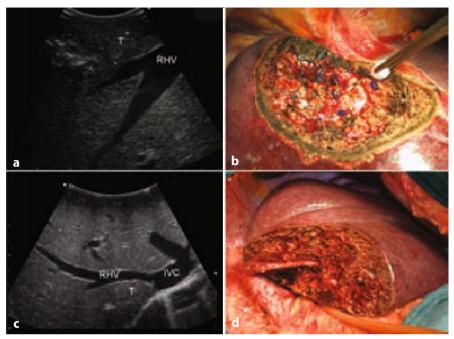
Parenchymal-sparing strategy in resection of colorectal liver metastases. (a) Intraoperative ultrasonography shows a metastasis in contact with the right hepatic vein without infiltration. (b) Wedge resection of segments 7 and 8 sparing the right hepatic vein that has been exposed on the raw cut surface. (c) Intraoperative ultrasonography shows a metastasis compressing (but not infiltrating) the right hepatic vein. (d) Resection of Sg7 with exposure of the right hepatic vein on the raw cut surface
